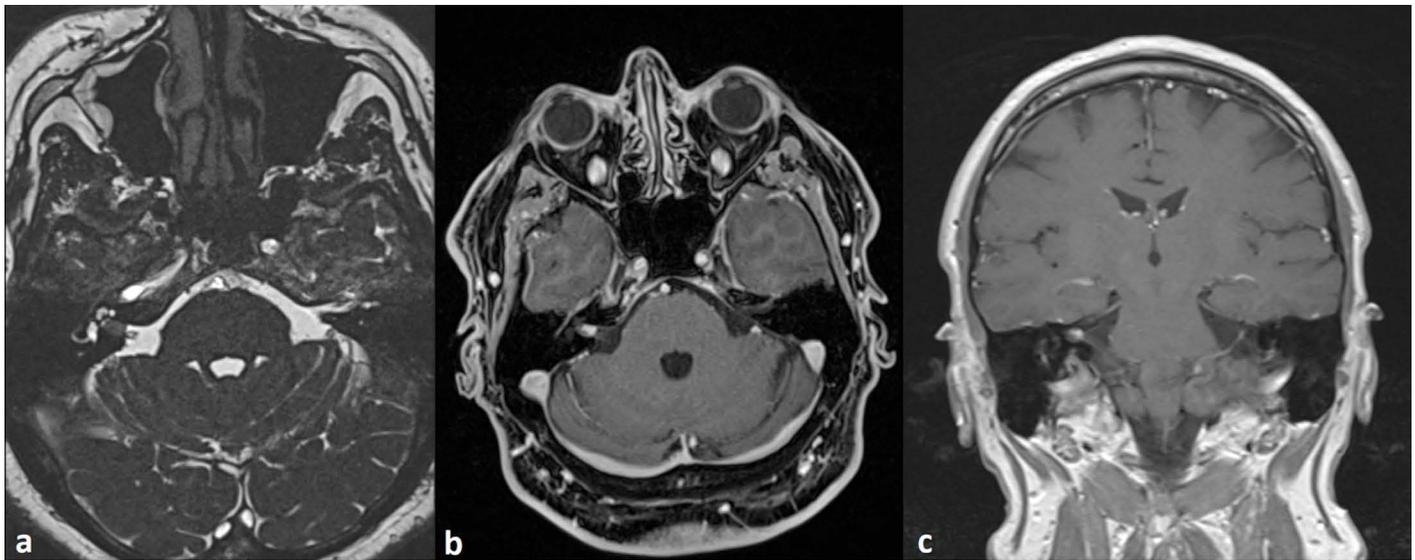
MRI scan of the internal acoustic canal: a – FIESTA sequence, axial projection; b – T1-weighted image with contrast, axial projection; c – T1-weighted image, coronal projection.
